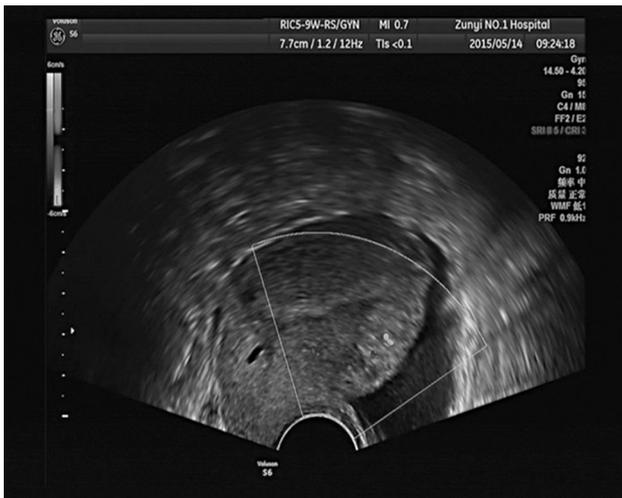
Transvaginal ultrasonography of the patient. The size of the mass was 6.1×5.5×4.1 cm. Blood flow signals around the mass.
